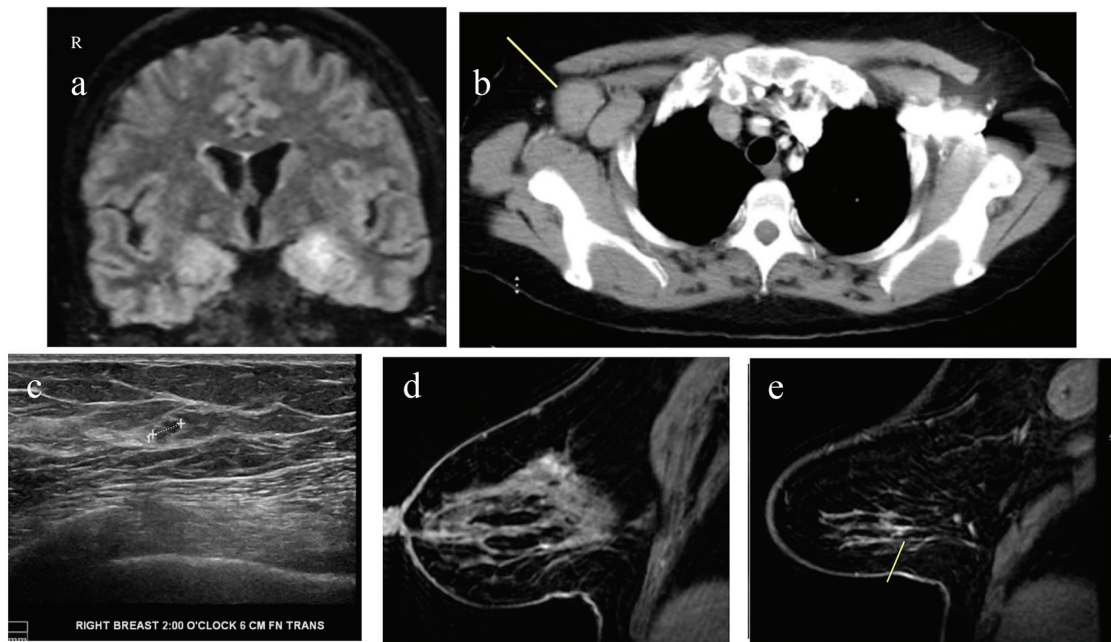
(a) MRI of brain with and without contrast showing T2/FLAIR hyperintensity along the medial temporal lobe involving portions of the hippocampus and amygdala. (b) CT of chest with contrast showing markedly enlarged axillary lymph nodes. (c) Ultrasound of right breast and axilla showing 4 × 4 × 3 mm hypoechoic lobulated nodule at 2 o'clock axis. (d) MRI of bilateral breast with and without contrast showing clumped enhancement in the upper outer quadrant of the right breast. (e) MRI of bilateral breast with and without contrast showing a small 8 mm area of patchy non-mass enhancement in the lower outer right breast.
